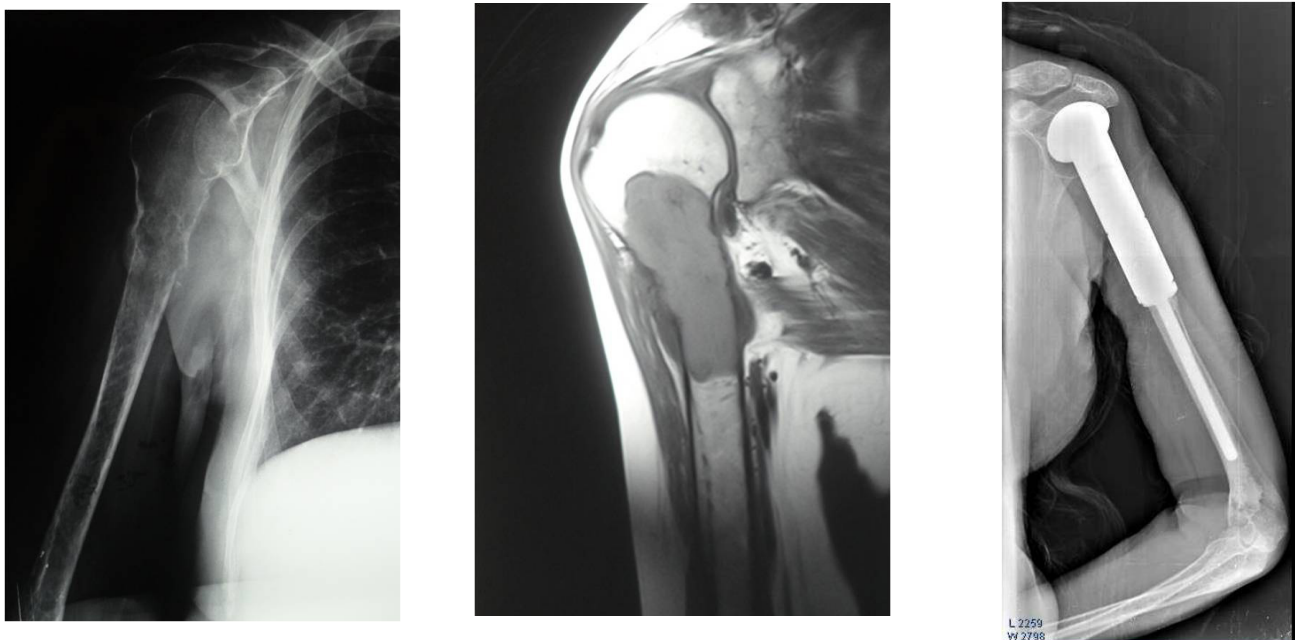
Pathological fracture accompanied by a minimal deformity located in the proximal humerus of a 58-year-old female patient diagnosed with multiple myeloma (a,b). Control x-ray of the third postoperative year following wide resection and endoprosthetic replacement operation (c).
